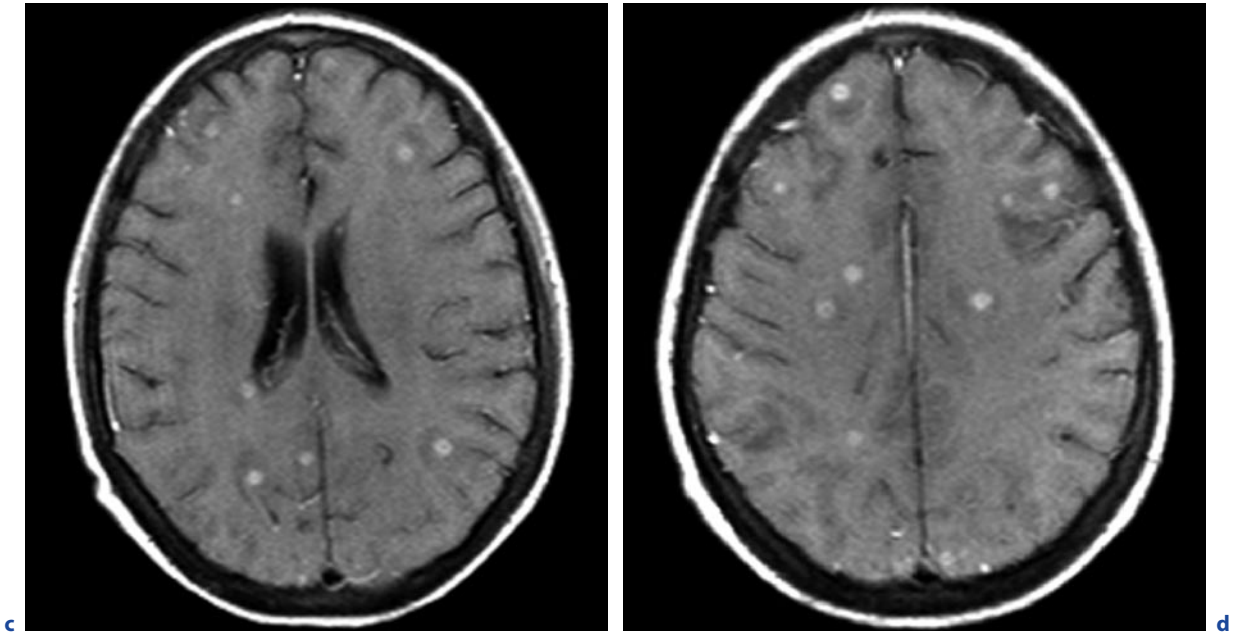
(continued) Systemic nocardiosis with CNS involvement in a 16-year-old immunosuppressed boy. c,d T1-weighted images after contrast administration. Multiple foci of signal alterations with enhancement and perifocal oedema
